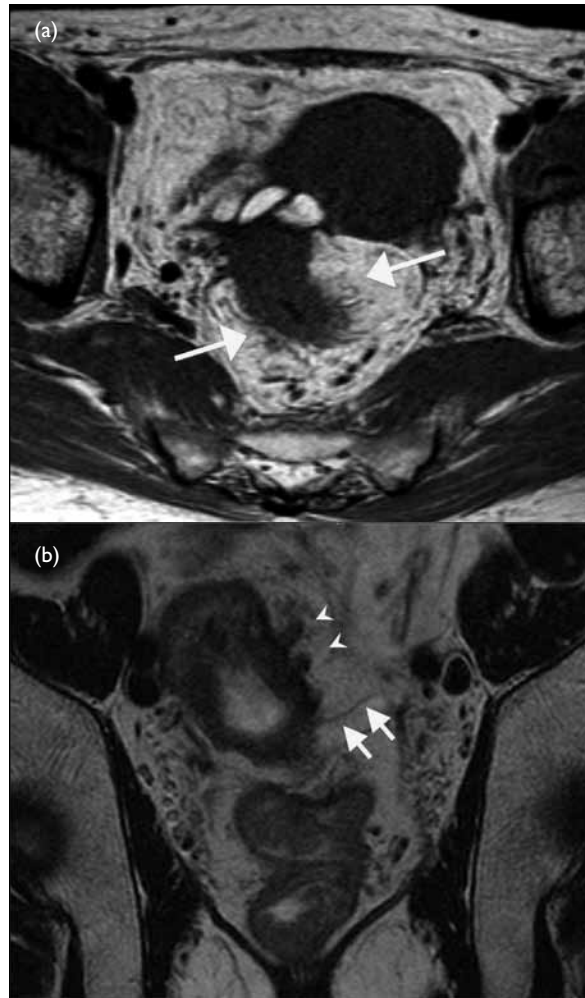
(a) T1-weighted axial image showing spiculation and stranding in perirectal fat, suggesting subserosal invasion (arrows); pathologically proven T3 tumour. (b) Coronal T2-weighted image showing a large rectal tumour involving the rectosigmoid junction. The arrows indicate the mesorectal fascia. Invasion into the peritoneal cavity (arrowheads) is evident; pathological examination showed a T4 tumour
